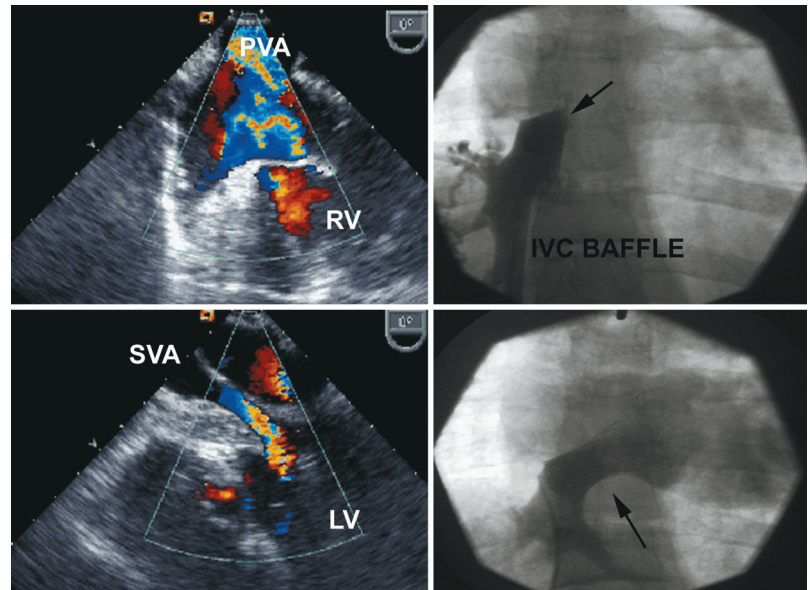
Montage of post-Mustard procedure cases. The angiogram in the right upper panel shows complete obstruction of the inferior limb of the systemic venous baffle, whereas the lower right panel is the same case after stenting. The upper left image is a transesophageal echocardiogram showing the pulmonary venous baffle with some mild flow acceleration in its midpoint. The lower left panel shows the systemic venous baffle at its left ventricular end. IVC = inferior vena cava; LV = left ventricle; PVA = pulmonary venous atrium; RV = right ventricle; SVA = systemic venous atrium.
